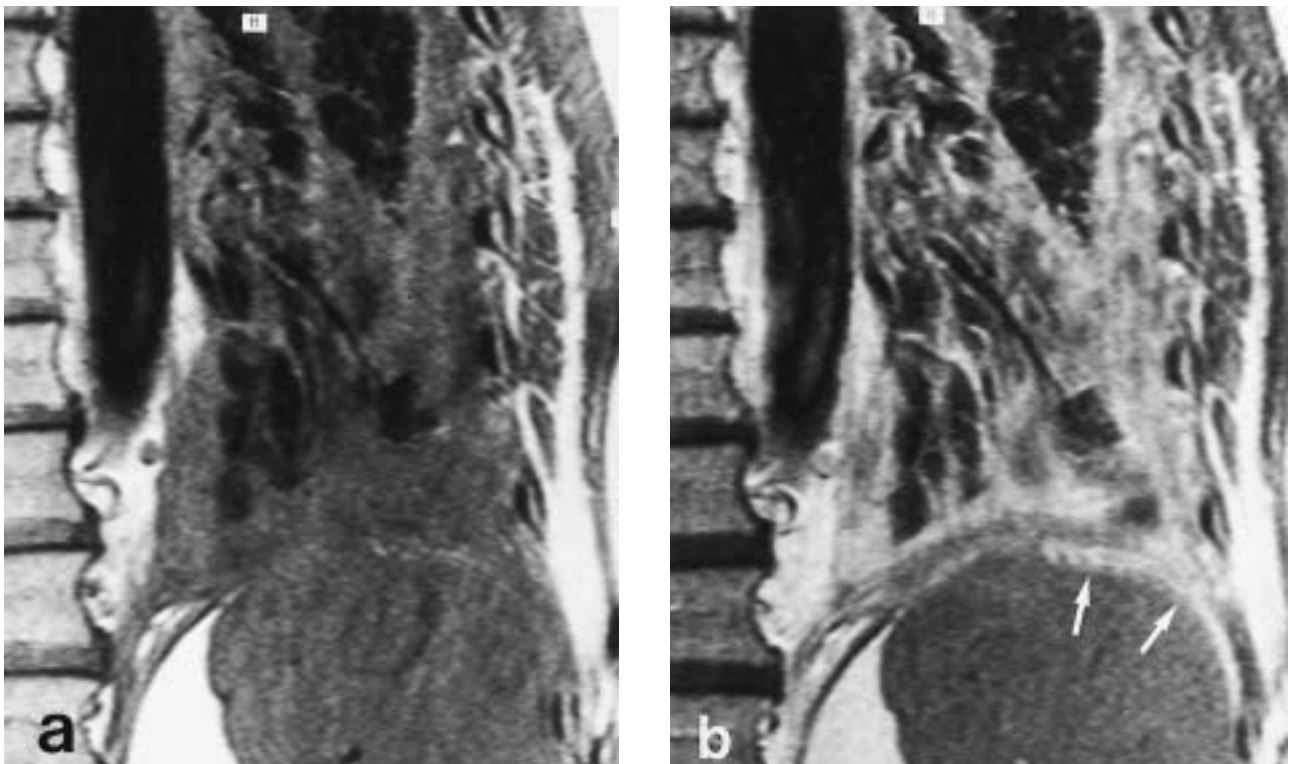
Tumour invasion of the diaphragm. a) Unenhanced and b) contrast-enhanced coronal T1-weighted magnetic resonance images in malignant pleural mesothelioma show intense band-shaped enhancement of the lateral diaphragm (arrows), representing tumour invasion (surgically confirmed).
